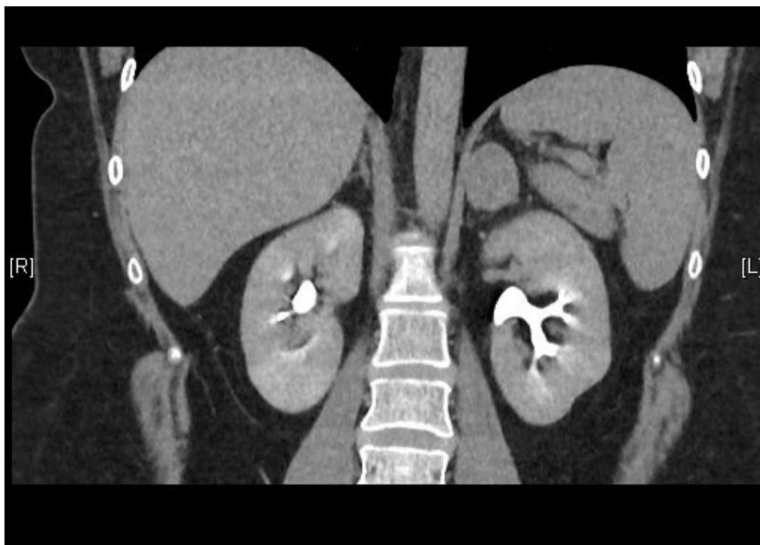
Adrenal CT demonstrating left adrenal lesion
